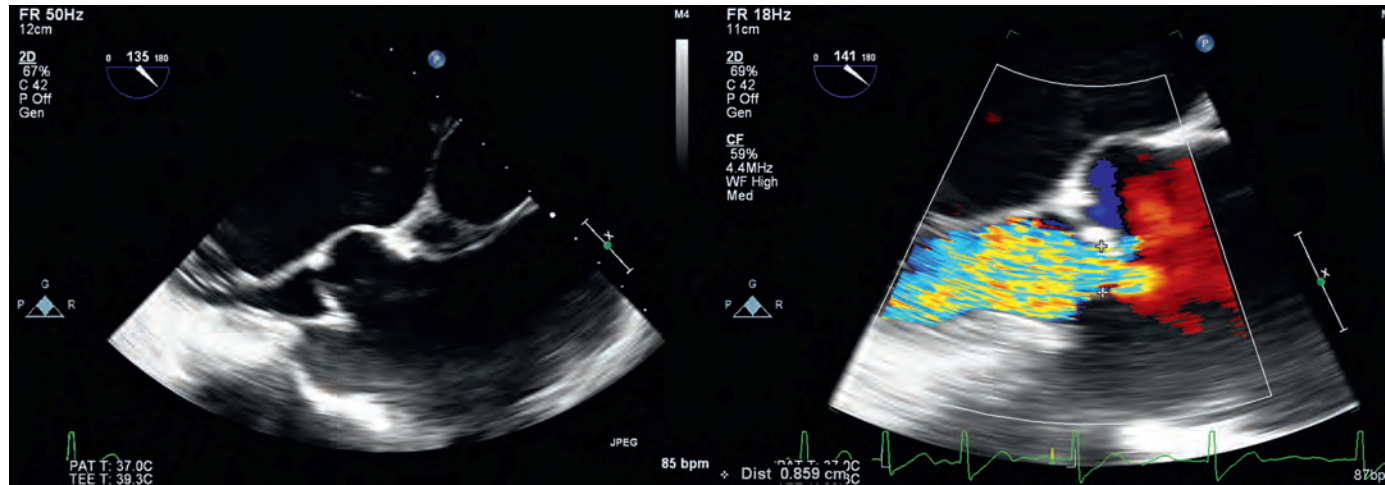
Type I aortic regurgitation. Midesophageal aortic valve long-axis view demonstrates functional aortic regurgitation, secondary to an ascending aortic aneurysm. (Left) The sinus of Valsalva is very enlarged with respect to the aortic valve annulus. This enlargement results in the tethering of the aortic valve. The coaptation plane of the aortic leaflets are significantly distal to the plane of the aortic annulus. (Right) Addition of color-flow Doppler demonstrates severe aortic regurgitation. (Video available online.)
